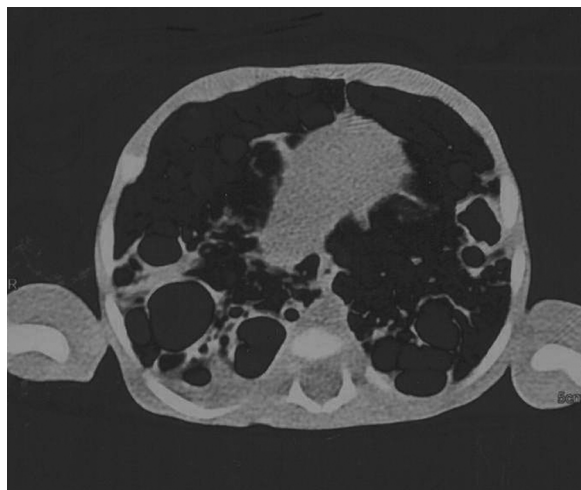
Cavitation lesions on chest computed tomography on day 23 of hospitalization in the neonate with extensive pulmonary infiltrates who survived.
